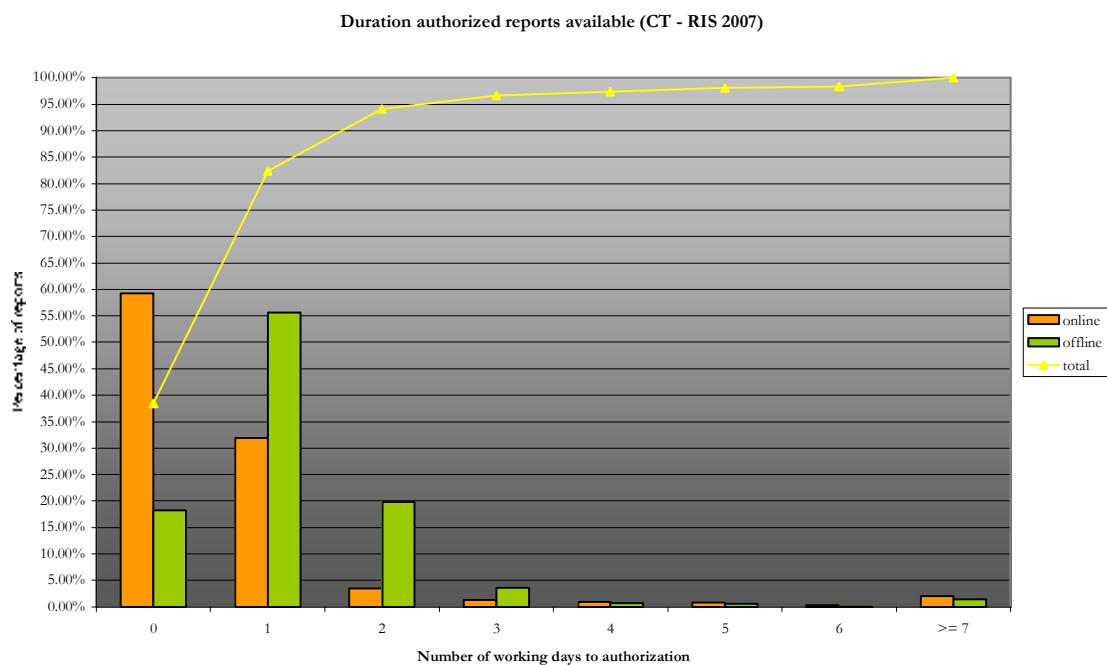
Throughput time radiology report CT-scanner: online versus offline (RIS 2007)
